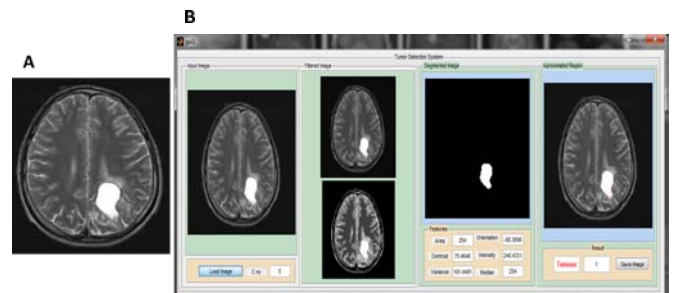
Analysis of brain MR image of 38 year old woman diagnosed with astrocytoma. A. Input MR brain image. B. Loading of a brain image, its filtered, segmented and approximated region of tumor.
